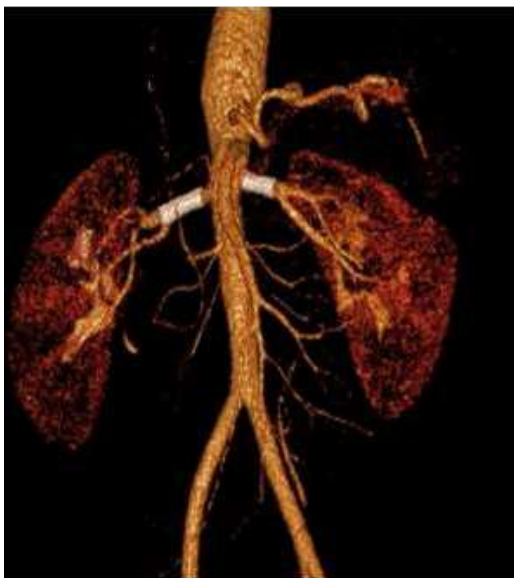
CT Aortogram of bilateral Renal Artery Stents
